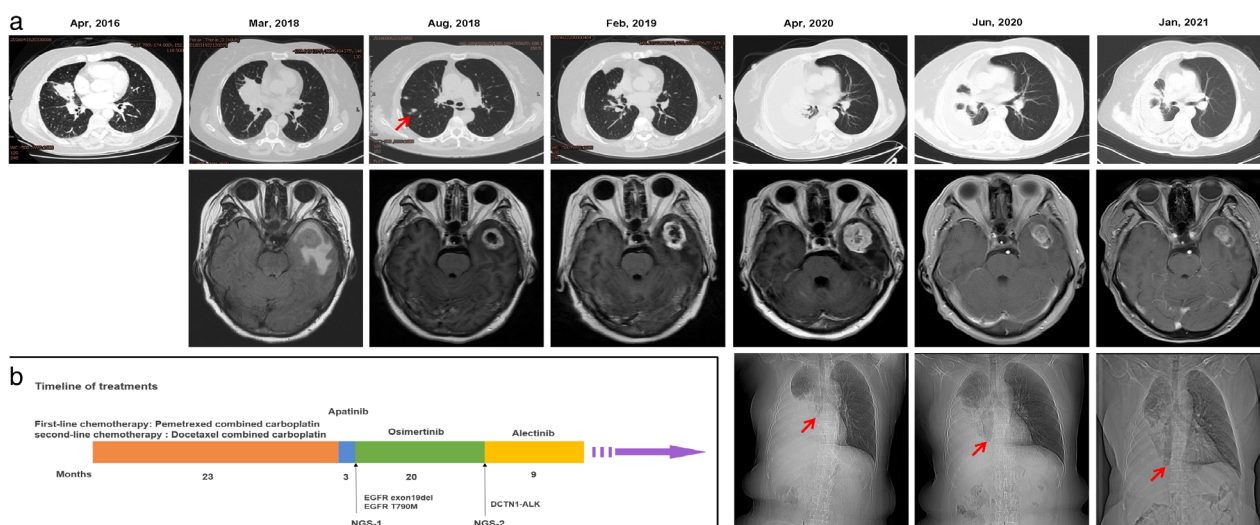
The patient's treatment history and chronological imaging follow-up results. (a) Chest CT, brain MRI, and chest X-ray images of the patient before and after treatment. The red arrow in the chest CT of August 2018 indicates new metastases in the lung; the red arrows in the chest x-rays of April 2020, June 2020, and January 2021 indicate the pleural fluid line. (b) Timeline of multiline treatment and summary of the duration of each treatment
